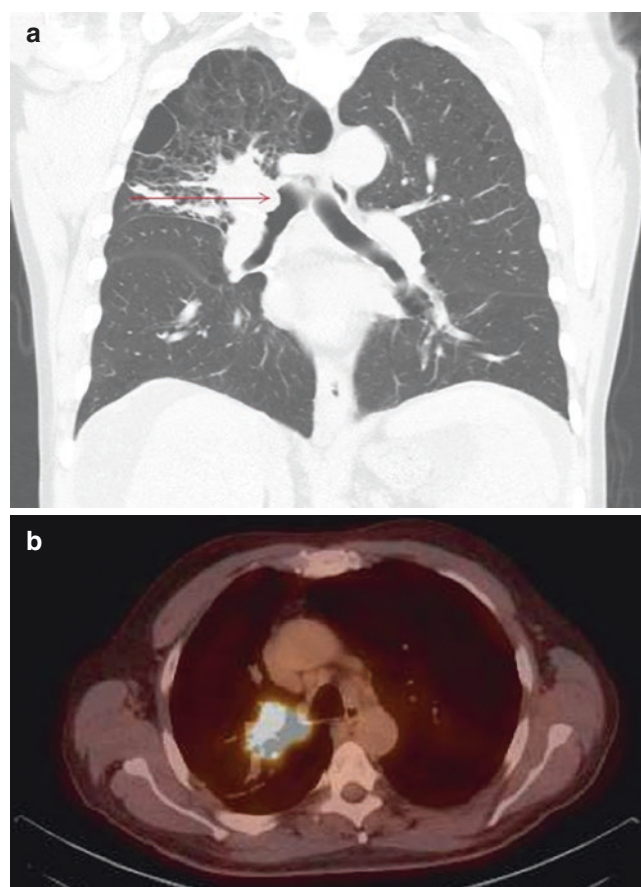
(a) Computed tomography revealed a right upper lobe mass extending into the right mainstem (arrow) and post-obstructive pneumonitis of the right upper lobe. (b) A positron emission tomography scan showed no distant or nodal metastasis
